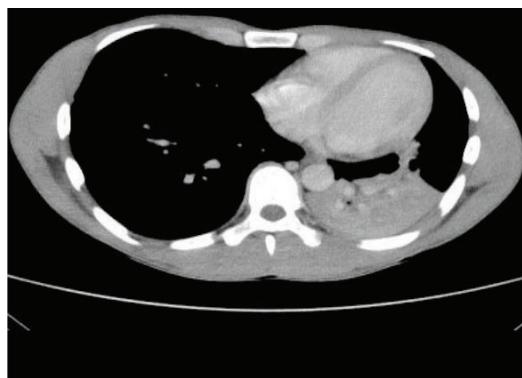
CT showing Pneumomediastinum
